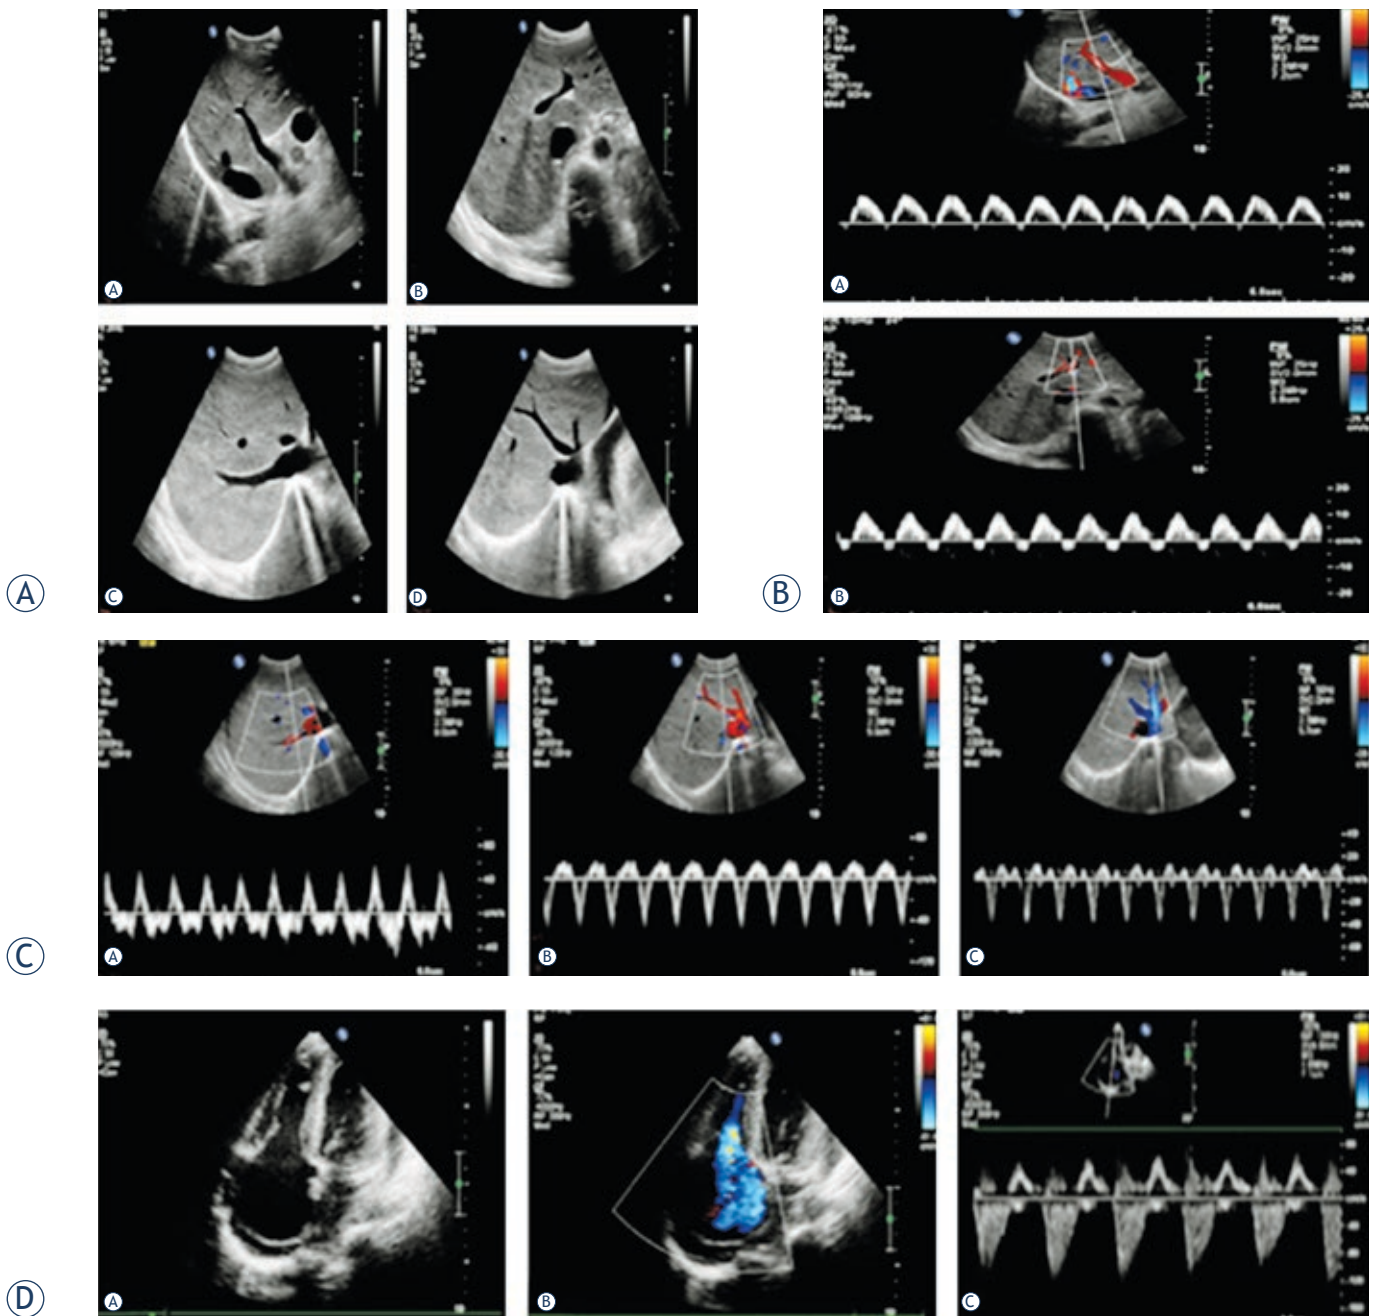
CTS with severe tricuspid regurgitation. (A) Normal US scans demonstrate normal internal diameters of the portal and hepatic veins (a: right branch, b: left branch, c: right hepatic vein, d: middle and left hepatic vein). (B) The waveform of velocity tracing in the intrahepatic branch of the portal vein shows a typical hump-like shape with a transitory hepatofugal tracing (a: right branch, b: left branch). (C) PW displays an increase of retrograde phase of hepatic venous flow with increased velocities in the two phases (a: right hepatic vein, b: middle hepatic vein, c: left hepatic vein). (D) Echocardiography shows an enlarged right atrium with severe tricuspid regurgitation (a: Normal ultrasound scans, b: CDFI, c: PW).
